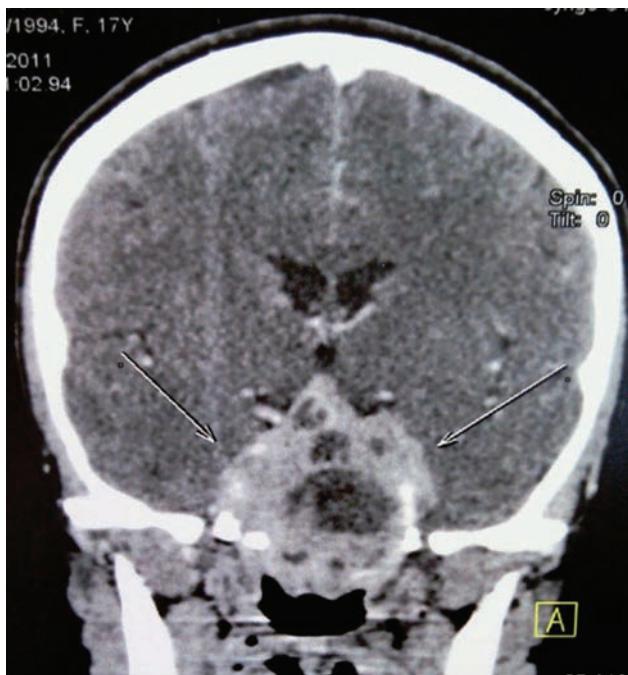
Contrast-enhanced, coronal head computed tomography showing a tumor mass with invasive aspect, bilateral involvement of the cavernous sinuses and superior extension to the optic-chiasmatic cistern.
